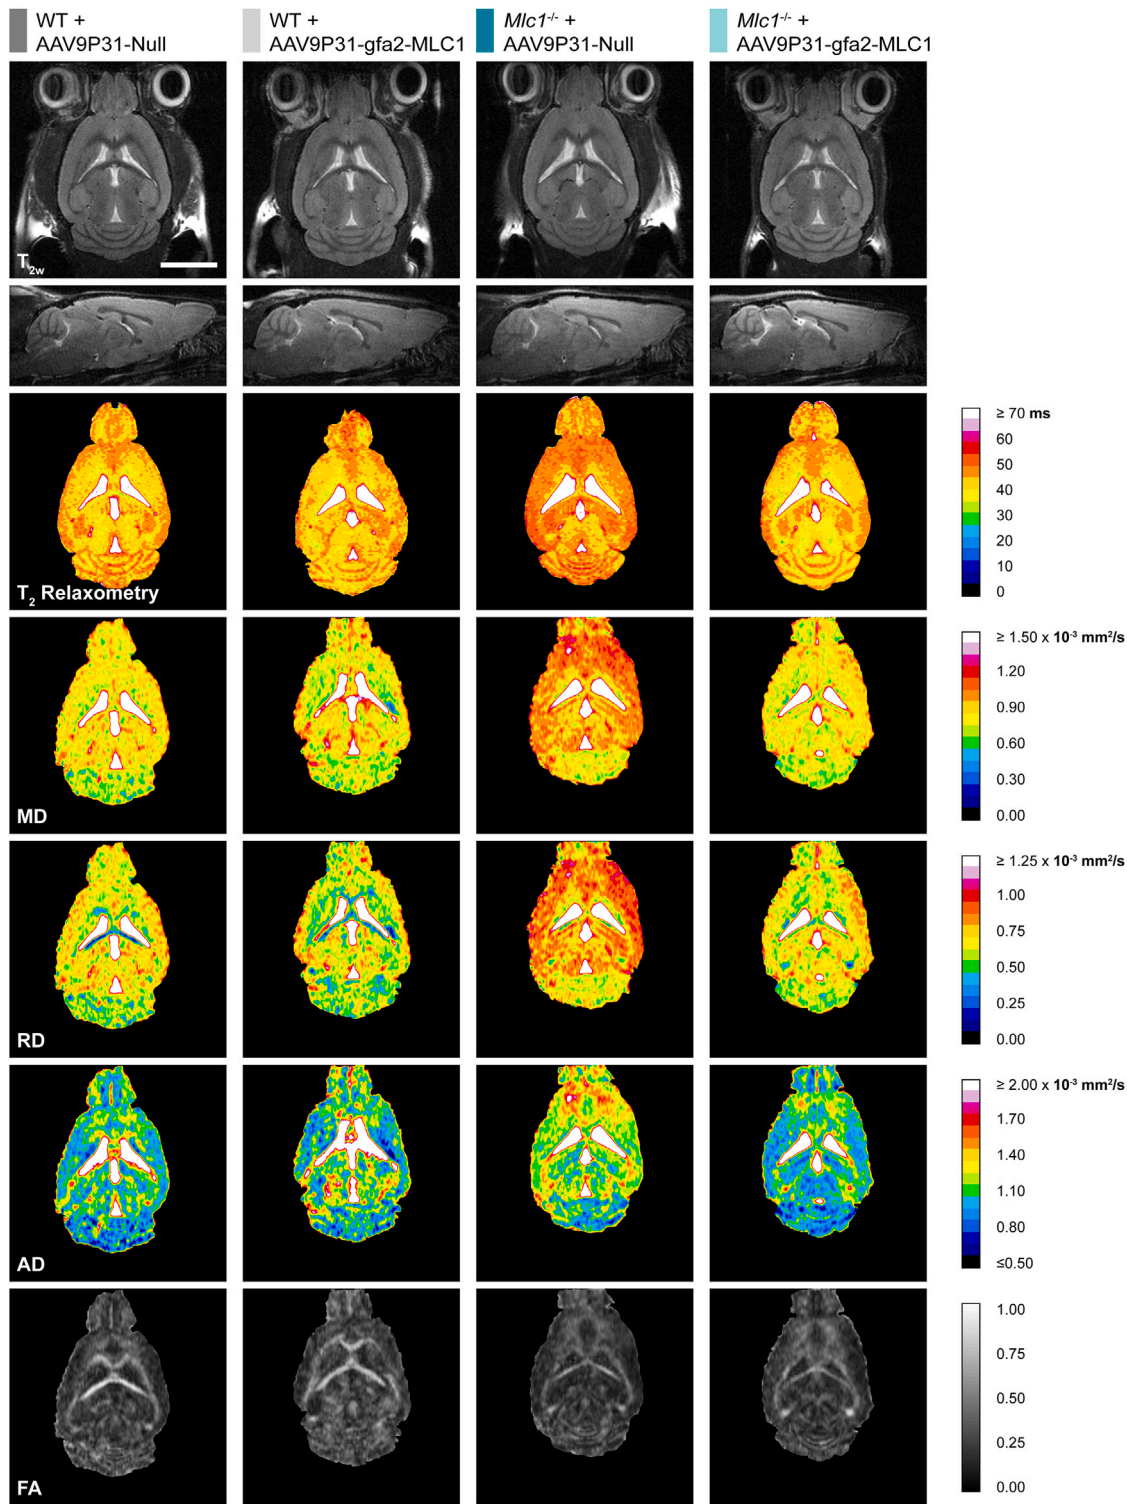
Magnetic resonance imaging
